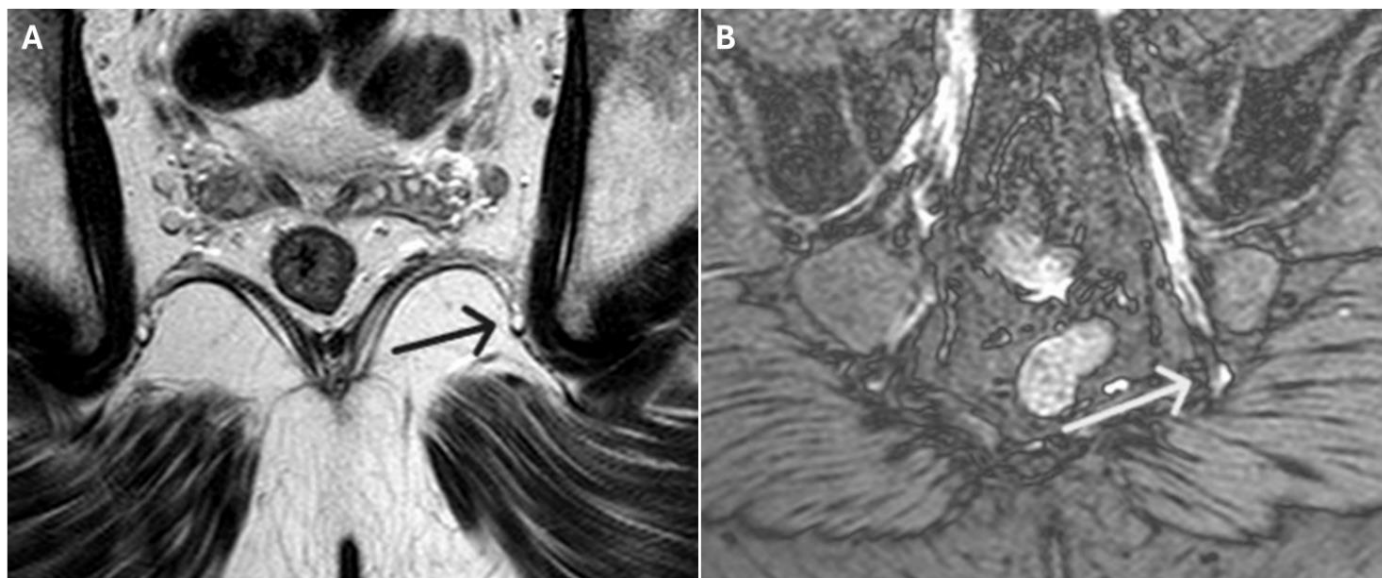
Grade 2 pudendal neuropathy at the nerve's entry into Alcock's canal. MR neurography, coronal oblique view: Side-by-side comparison of TSE T2-weighted image (a) and double IR BB sequence (b) shows clear identification of the pudendal nerve in end-on view (arrows), with hyperintense signal just below the ischial spine, unobscured by overlapping structures.
